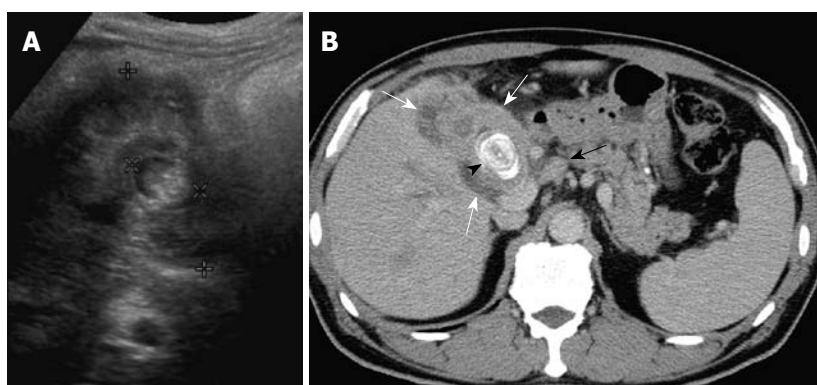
A 77-year-old woman with right upper abdominal pain and jaundice for 1 mo. A: US showed a large gallstone (x cursors) encased by the diffusely thickened gallbladder wall, with a heteroechoic appearance (+ cursors); B: Contrast-enhanced CT showed diffuse, uneven wall thickening of the gallbladder (white arrows), with a large laminated gallstone (arrowhead) and hepatoduodenal ligament lymph node metastasis (black arrow).
